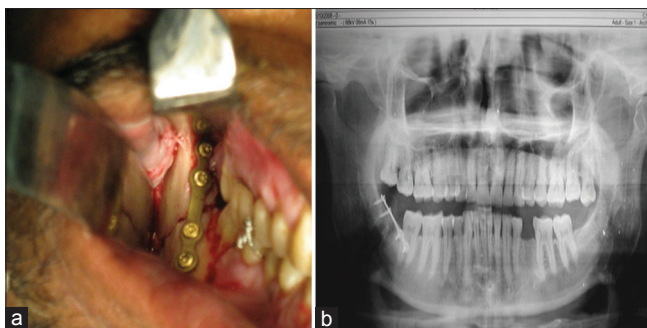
(a) Open reduction and internal fixation by locking plate and screw; (b) follow-up radiograph showing adequate reduction
